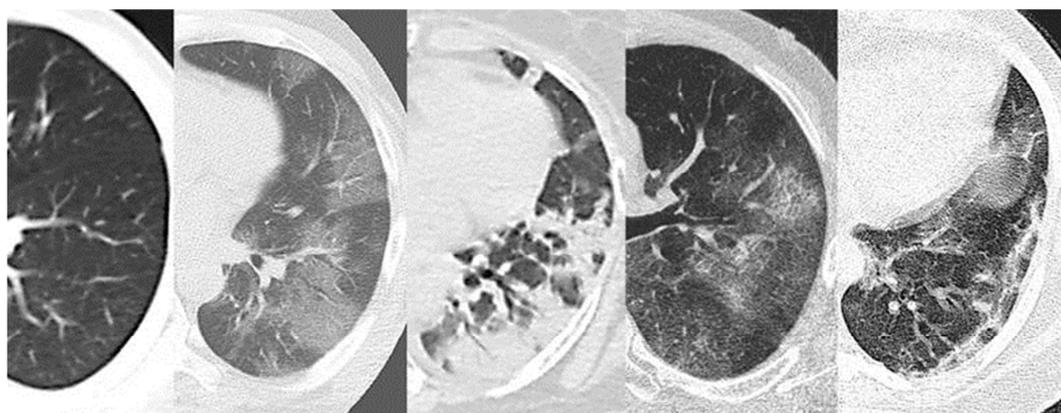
CT with examples of different tomographic patterns. From left to right: normal CT, ground glass opacities, consolidations, crazy paving and architectural distortion.
